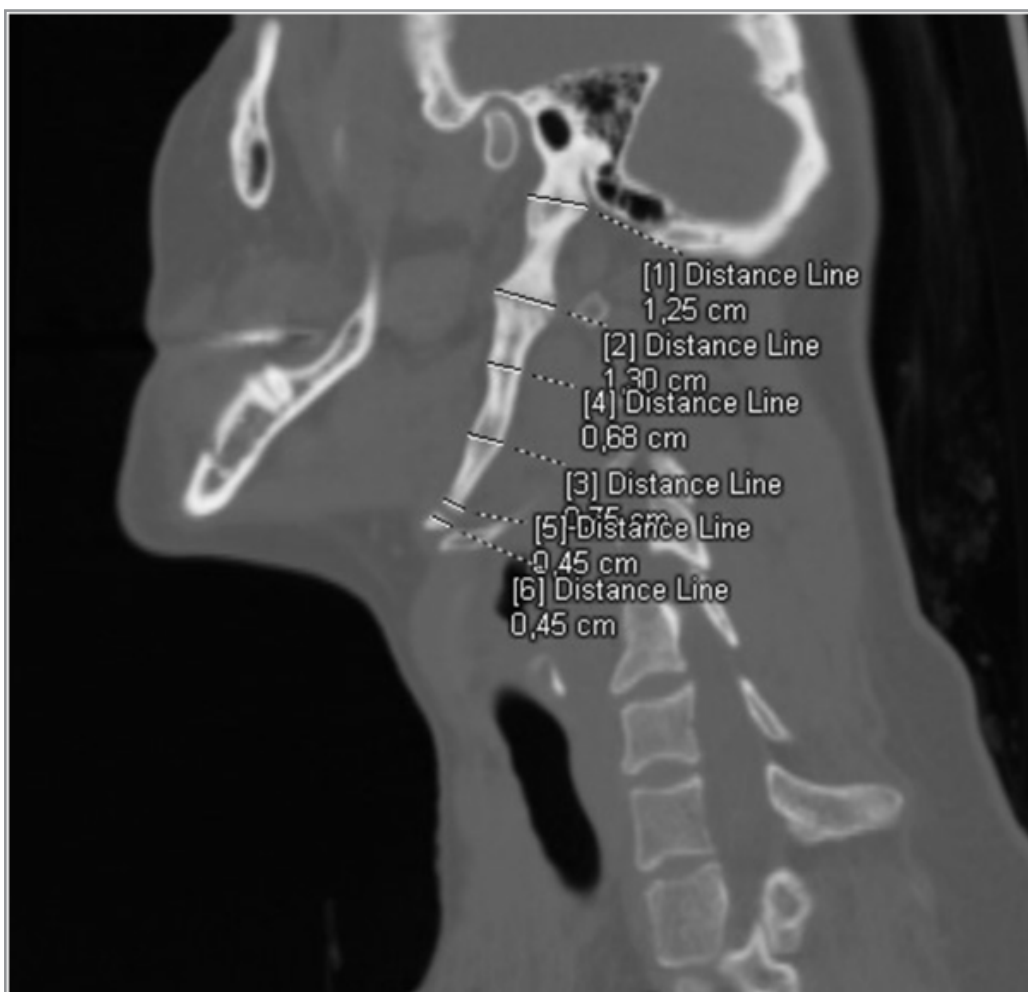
Multidetector computed tomography (MDTC) with 3D volumetric reconstructions (3D-VR) - left-sided sagittal view.
